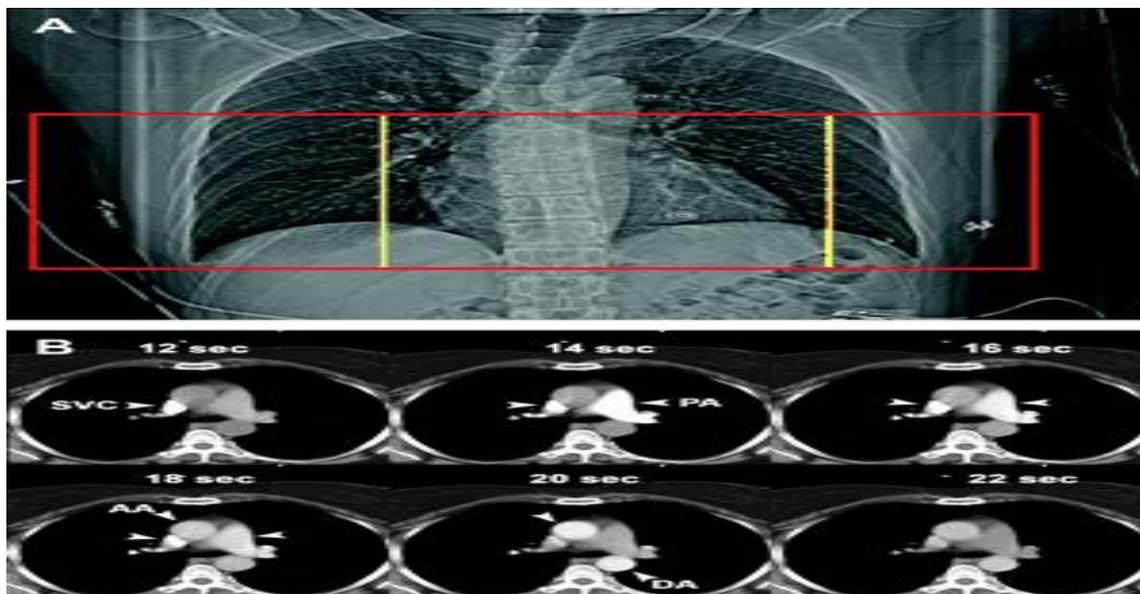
(A) Anteroposterior topogram showing volume coverage (field of view) required for dedicated coronary CTA (yellow box) and reading of incidental findings (red box). For coronary CTA, field of view extends from below tracheal bifurcation to base of heart. (B) Timing bolus image acquisition. Images at level
